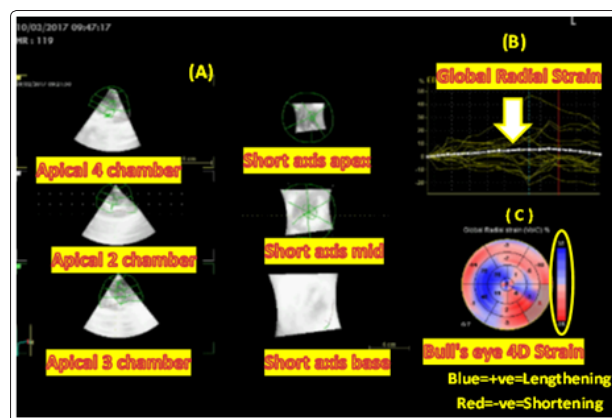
(A) 3D Strain results from a diseased neonate heart from left ventricular (LV) apical 4, 2 and 3 chamber long axis and LV short axis view at apex, mid-muscular and base, showing radial strain, (B) The upper part shows a plot with yellow traces for each of the 17 segments, in addition to a white trace for the global radial strain, (C) The lower part shows a colour coded bull's eye plot with instantaneous strain values. The instantaneous global strain is shown marked with a "G:" to the lower of the bull's eye plot; marked by yellow arrow.
